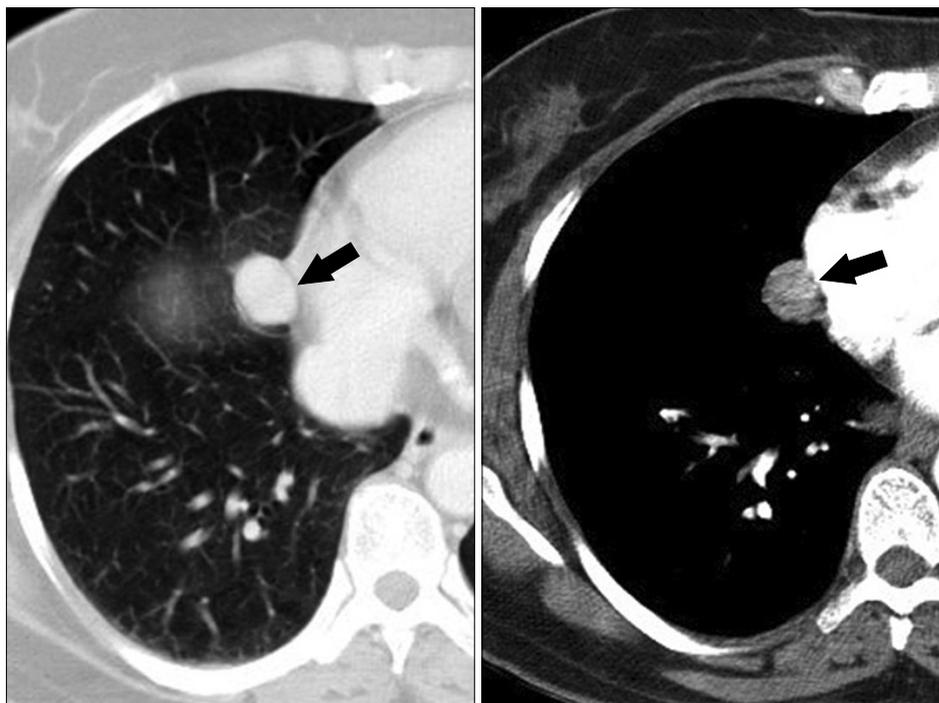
CT shows an oval well-enhancing mass in mediastinal pleural side at the right lower lung zone (arrows).
